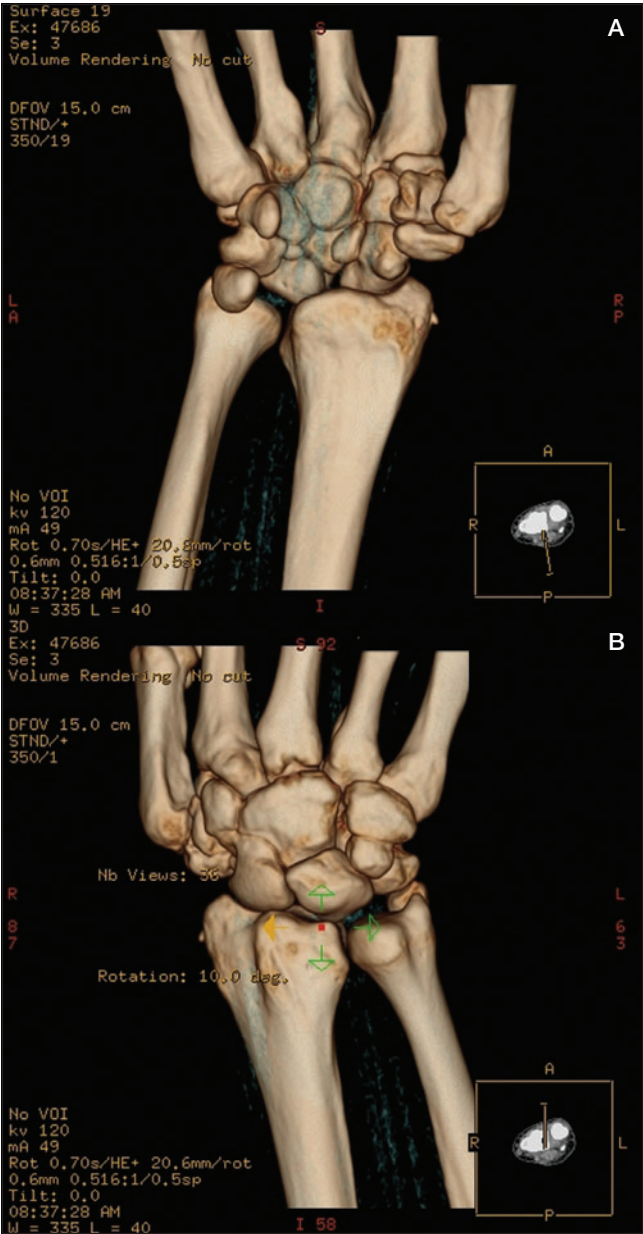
A Computed tomography scan of the right wrist with three-dimensional reconstruction (volar aspect). B Computed tomography scan of the right wrist with three-dimensional reconstruction (dorsal aspect)
